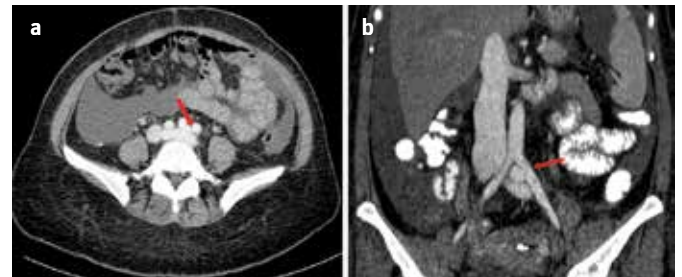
a, b. Axial abdominal CT scan demonstrated early opasification of the left common iliac vein and saccular aneurysm of proximal left iliac vein (Arrow) (a). Coronal reformatted abdominal CT demonstrated fistulization between the left common iliac artery and aneurysm (Arrow) (b).
